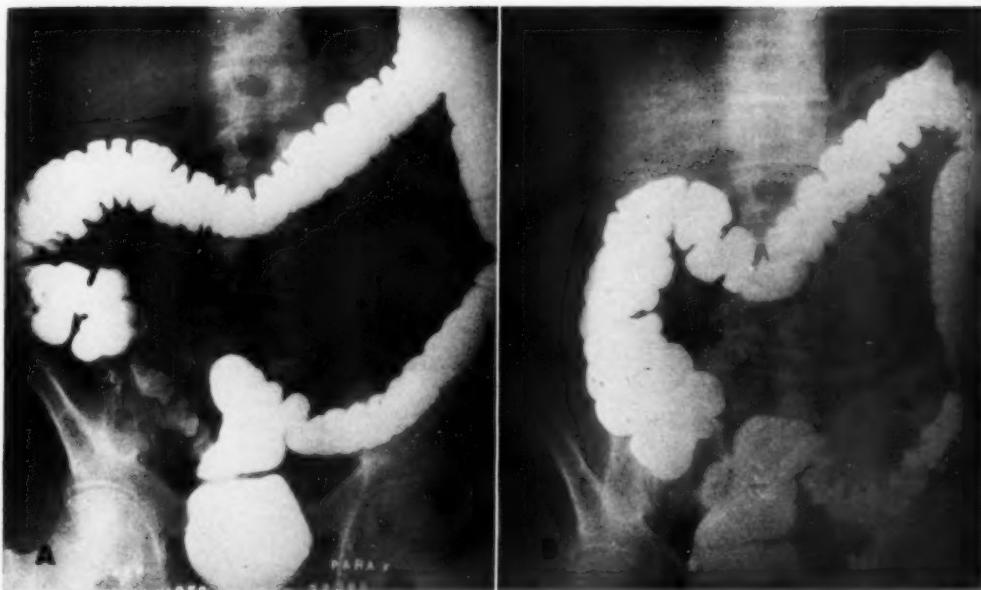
Case 1. Roentgenograms of the colon (barium enema study) to show non-visualization of a segment of the descending colon without flank compression and visualization of the missing bowel segment after flank compression.
